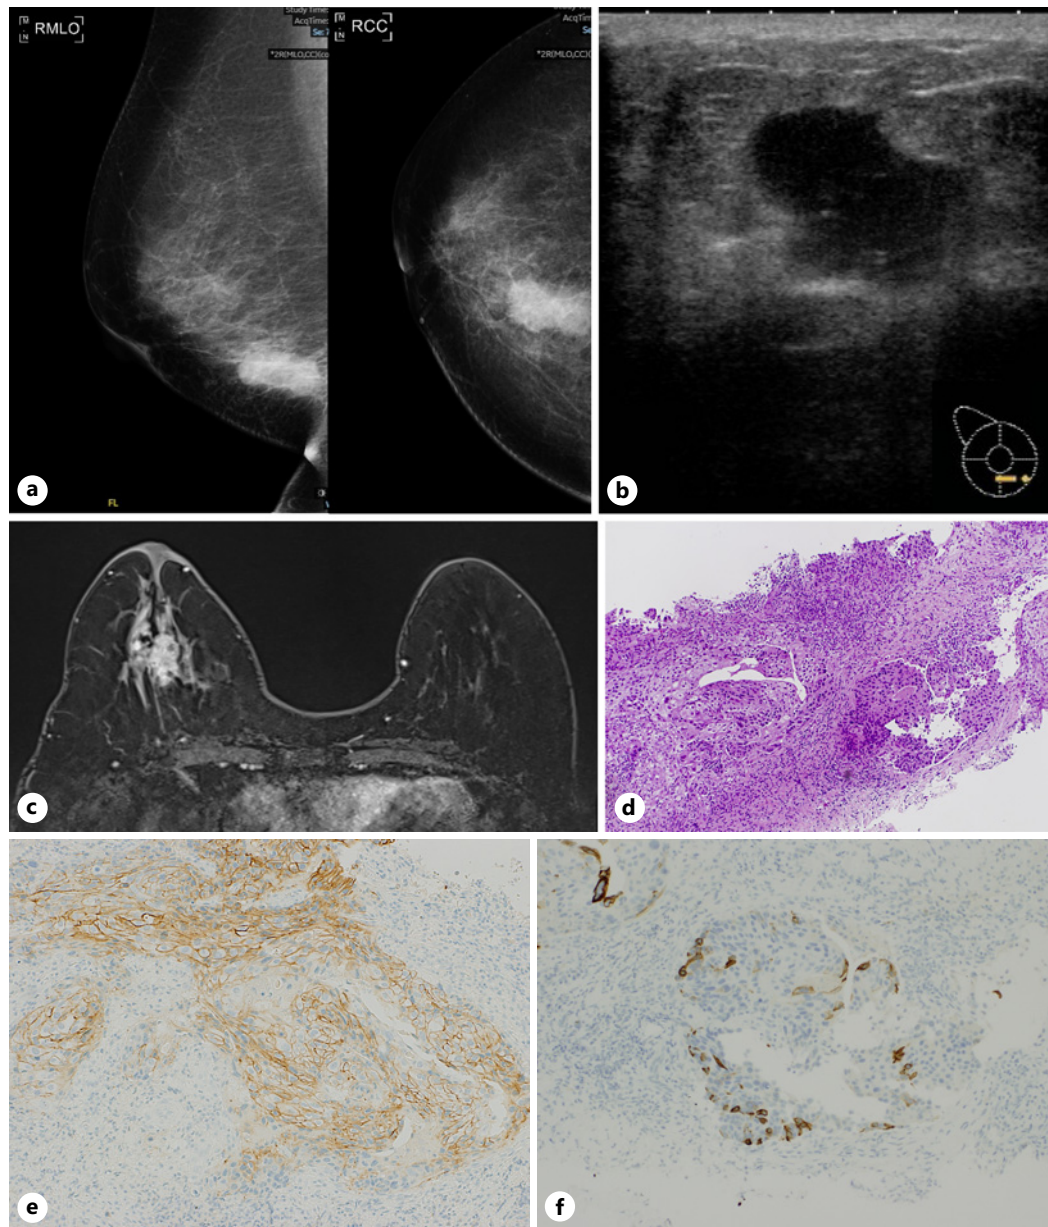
a Mammography revealed a lobulated and high-density mass in the left lower inner quadrant of the breast. b Ultrasonography showed a well-circumscribed and amorphous mass in the right breast that was 2.7 cm in size, had well-defined margins, enhanced posterior echoes, halo, and low-level internal echoes. c MRI revealed an amorphous mass with a pattern of early enhancement and washout. There was extensive ductal spread and a daughter nodule in the outside forward of the mass (arrow). d Pathological findings of core needle biopsy, showing atypical spindle cells with cobblestone appearance. e HER2 was overexpressed on the surface of the cancer cells (score of 3+). f CK5 was expressed on the part of the cancer cells.
